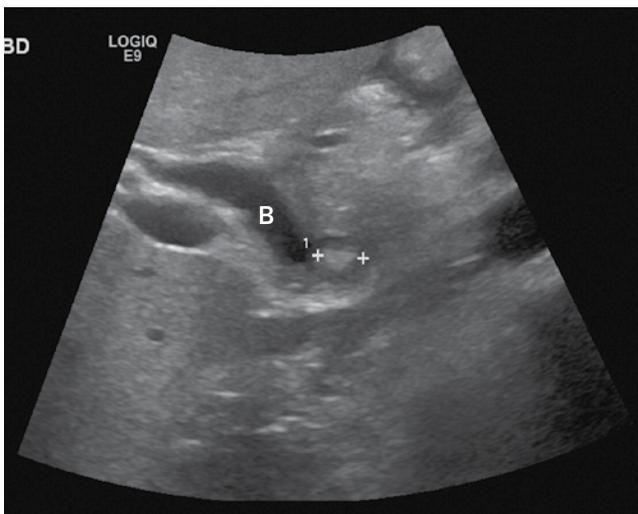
Ultrasound image showing dilated common bile duct (B) containing a calculus (between electronic callipers +).
